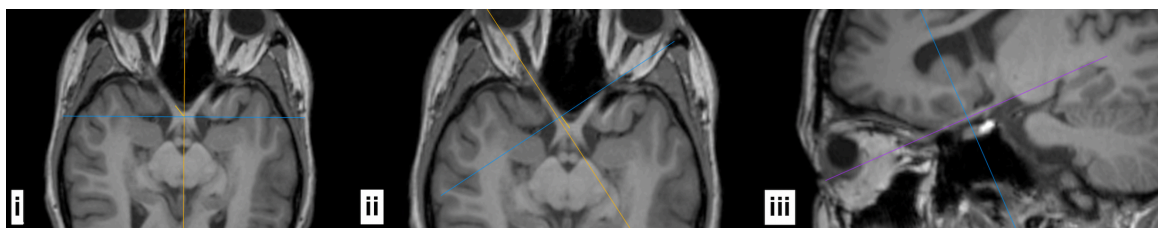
Adjustment of axis for optic nerve MRI measurement.
